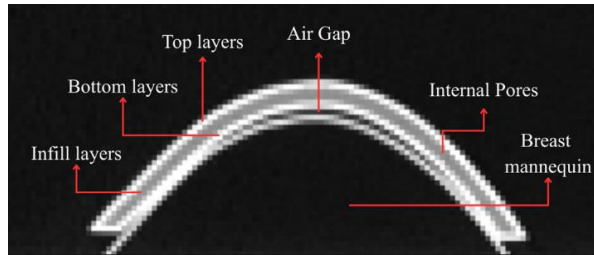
shows that air gaps were still present between the bolus and the mannequin breast, even though the bolus was fabricated based on CT images of the mannequin breast itself. This likely occurred due to the lack of transparency of the bolus material, which made it difficult to position the bolus accurately on the mannequin breast surface. Despite the limitations regarding the bolus material opacity, the observed air gap volumes presented in Table 5 are consistent with those reported in previous studies on nose-shaped 3D-printed Thermoplastic Polyurethane (TPU) and Polylactic Acid (PLA) boluses [19], and pelvic-shaped 3D-printed Polyethylene Terephthalate Glycol (PETG) bolus [37].
